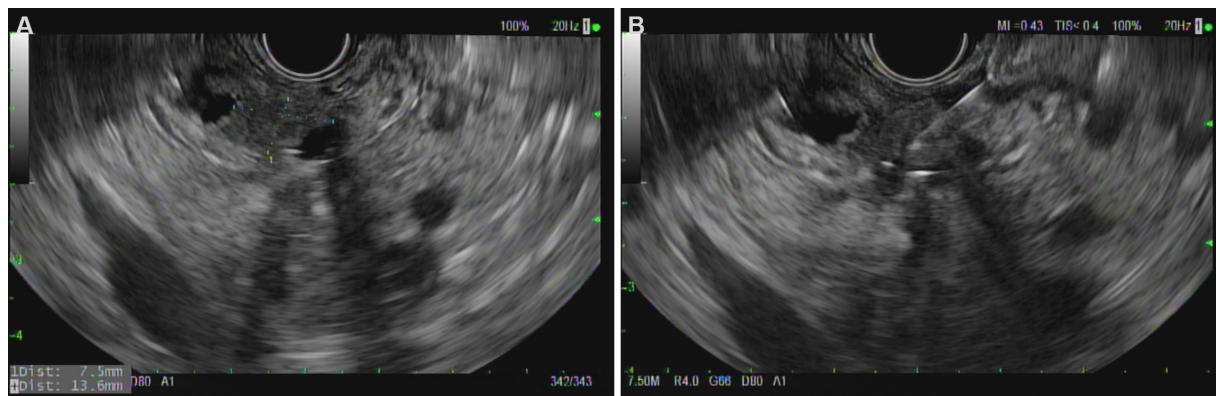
Endoscopic ultrasound demonstrating (A) mass in the distal bile duct in a patient with cholangiocarcinoma (B) fine needle aspiration of the mass.
